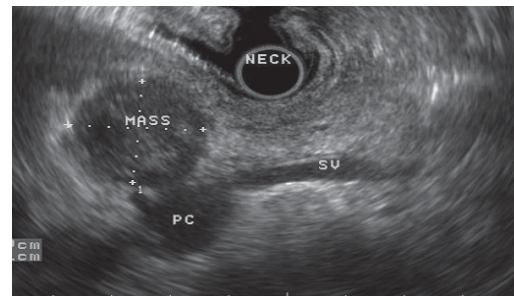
Endoscopic ultrasound (EUS) showing a 2.5 cm hypoechoic mass (MASS) at the pancreatic genu/neck adjacent to the portal confluence (PC) and splenic vein (SV).
